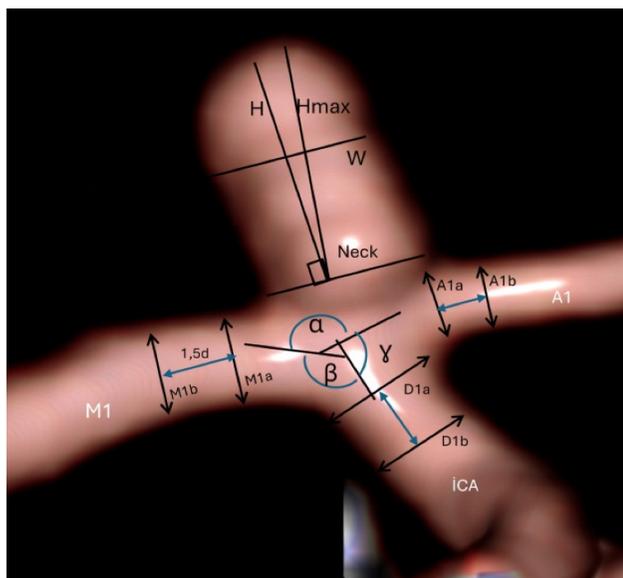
Computed tomography angiography (CTA) three-dimensional model of an internal carotid artery bifurcation aneurysm (ICAbifAn) depicting morphological variables of the surrounding vasculature.
